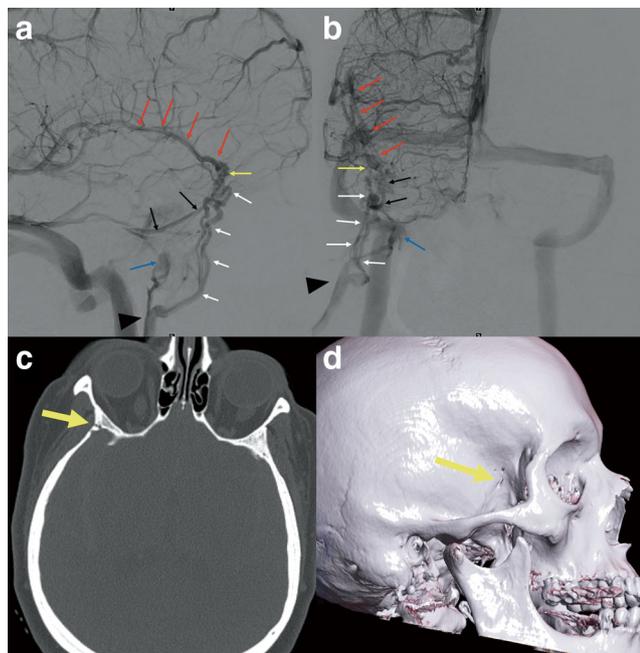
Lateral (a) and anteroposterior (b) view of the venous phase of the right internal carotid angiogram, axial image (c) and 3D volume rendering image (d) of CT scan (bone windowing). The right superficial middle sylvian vein (red arrows) is directly drained to the two deep facial veins (white arrows) and also drained via a paracavernous sinus (black arrows) to the pterygoid plexus (blue arrows), both of which empty into the same common trunk (black arrowhead). In the bone CT (c, d), the bone canal (yellow arrow) was found where the aberrant venous channel is located
